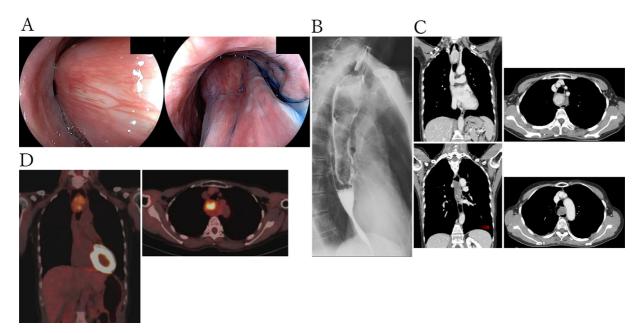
A: On endoscopy, a large, rod-like lesion covered in normal mucosa occupied most of the lumen in the esophagus 19-32 cm from the dental arch. B: On esophagography, a large mass lesion 15 cm in length and 3 cm wide was attached to the anterior wall of the cervical esophagus and occupied the cervical to mid-thoracic esophagus. C: On contrast-enhanced CT, a mass extending cephalocaudally into the esophagus. An intense enhancing effect was seen on the cephalic side (upper image), whereas the caudal side was less strongly enhanced (lower image). D: Positron emission tomography (PET)/CT revealed increased tracer uptakes at the upper to middle thoracic esophagus.
